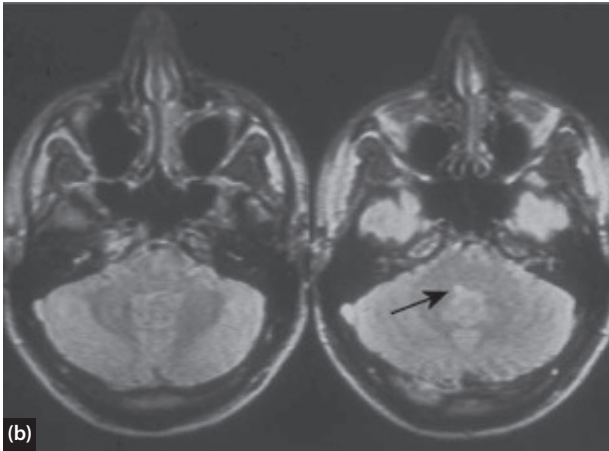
(a) Three-dimensional scleral search coiled oculography in a patient with a small demyelinating left-sided brainstem lesion, as shown on MRI (b) (arrow). The presence of a clinically observable torsional component in the spontaneous right beating nystagmus indicated that the lesion was central rather than peripheral. H, V and T are horizontal, vertical and torsional eye recordings. Left side of the brain is on the left side of the scan.
